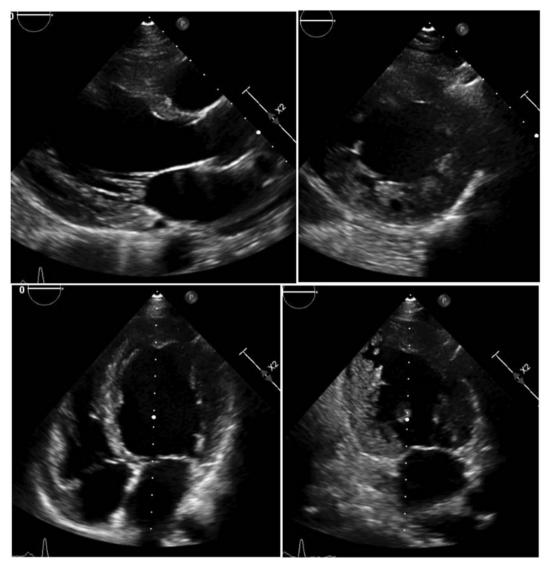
Echocardiography revealed LV dilatation, hypertrophy, and non-compaction. LV-EF was moderately reduced.
